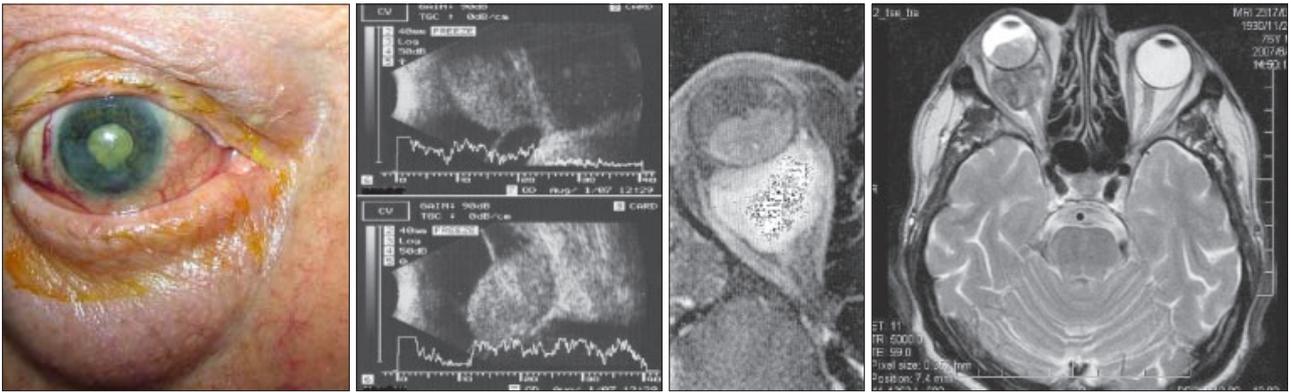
a) Clinical findings before therapy, mature cataract, hyphaema, neovascularisation of the iris, b) Ultrasound A, B modes, c) Computed tomography and magnetic resonance revealed a large well-circumscribed enhancing orbital tumor mass with intrabulbar and retrobulbar location, d) Magnetic resonance findings.
